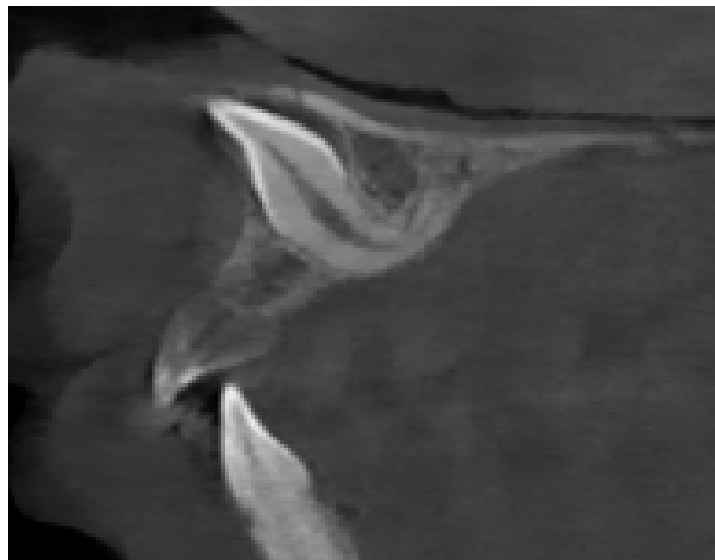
CBCT in sagittal section which highlights the dilacerated 21.
